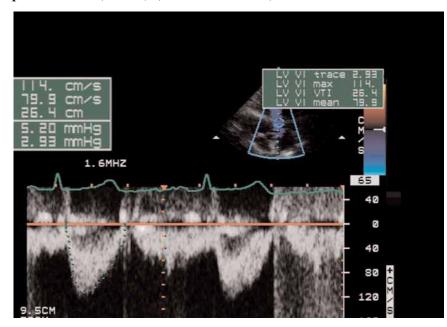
Pulsed Doppler through the left ventricular outflow tract. The waveform demonstrates the velocity of blood (*y*-axis), with time on the *x*-axis. (Solmon, 2003)
